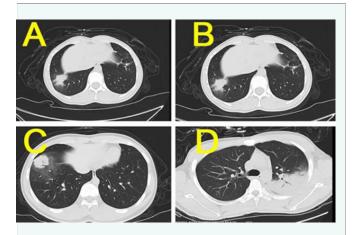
Chest CT Findings in Patients with Pneumonia Caused by Adenovirus Type 55.
